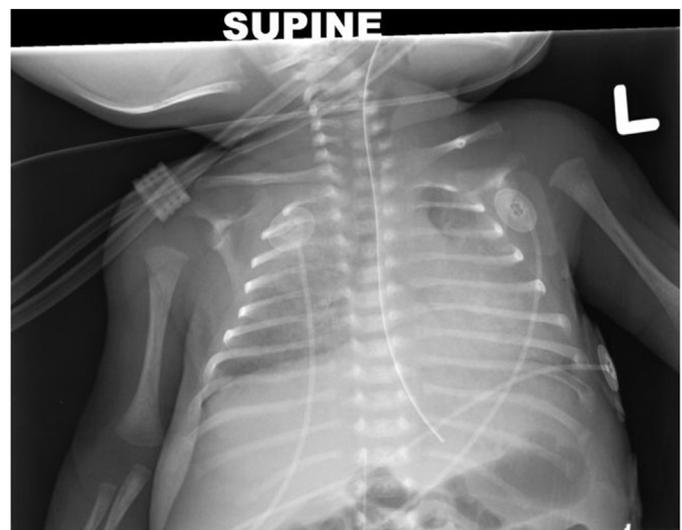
anteroposterior supine radiograph obtained portably demonstrates low lung volumes with diffuse, bilateral, symmetrical granular opacities throughout the lungs.
